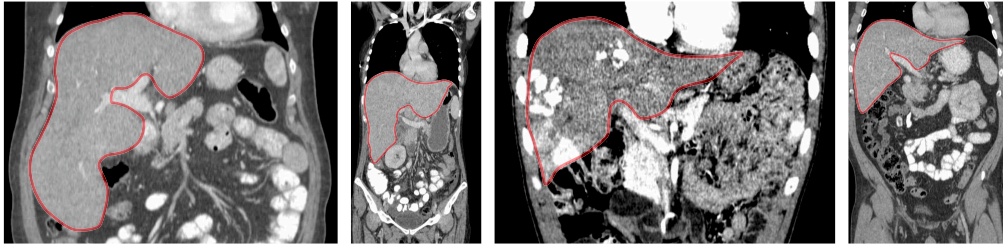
Examples of CT images (in coronal plane) for four different patients, showing the anatomical variability of the liver (in red) and variability of fields of view.
